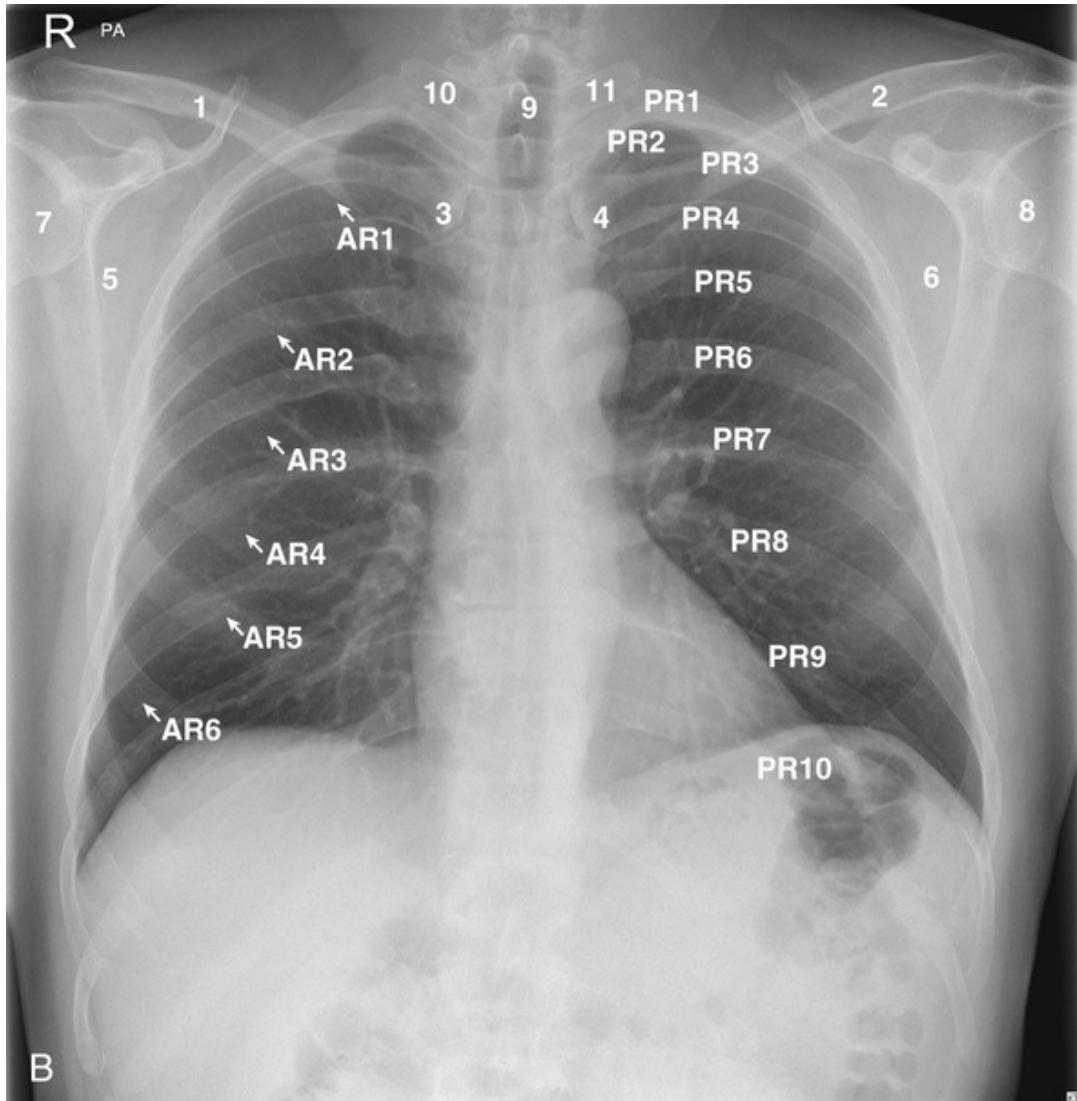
(A) The normal chest x-ray (CXR). Anatomic features: (1) Trachea; (2) Carina; (3,4) Right and left main bronchi; (5,6) Right and left hilar structures; (7) Right horizontal fissure; (8) Right cardiac border formed by right atrium; (9) Left cardiac border formed by left ventricle; (10) Aortic knuckle; (11) Descending thoracic aorta; (12) Right paratracheal line; (13,14) Right and left hemidiaphragms; (15,16) Costophrenic angles; (17) Gastric air bubble; (18) Gas in the colon. (B) Bony thorax. (1,2) Right and left clavicles; (3,4) Right and left sternoclavicular joints; (5,6) Right and left scapulae; (7,8) Right and left humeral heads; (9) Spinous process of T1; (10,11) Right and left transverse processes of T1; Anterior ribs (AR) 1–6; Posterior ribs (PR) 1–10.
